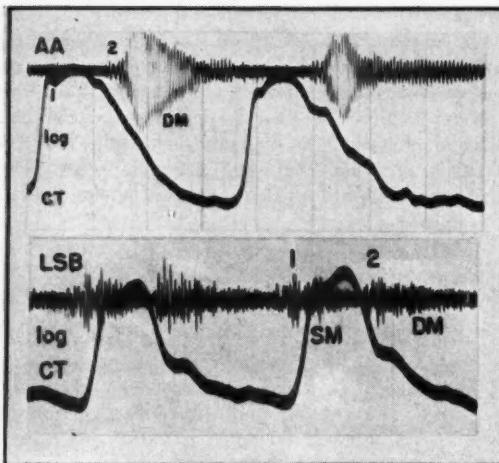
Top*—Aortic insufficiency. Syphilitic aortic insufficiency with rupture of aortic cusps. Note typical arterial diastolic murmur starting immediately after the second sound. Observe also the musical quality of the diastolic murmur as well as the absence of dicrotic notch in the indirect CT. *Bottom*—Pulmonary regurgitation in patient with ventricular septal defect and severe pulmonary hypertension (MPA = 80/30 mm. of mercury). Arterial diastolic murmur starting immediately after the second sound. Short systolic murmur.
